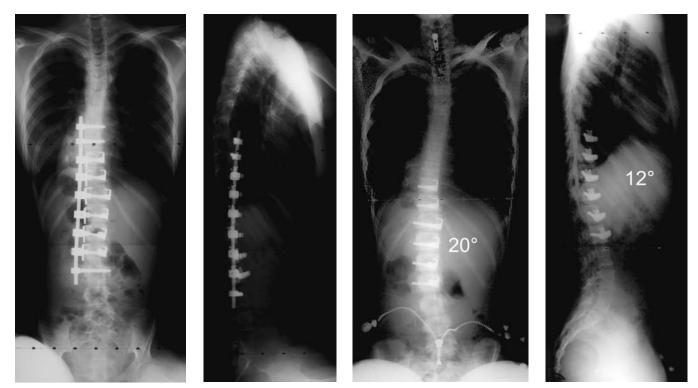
(Continued) (D,E) The patient underwent a wedge osteotomy from T10 to L3 with vertebral body screws in T8–T9 and L4 (she has six lumbar vertebrae). The lateral radiograph shows that the paralytic kyphosis is partly straightened but that some kyphosis is left to accommodate sitting. (F,G) The rod, screw heads, and staples
